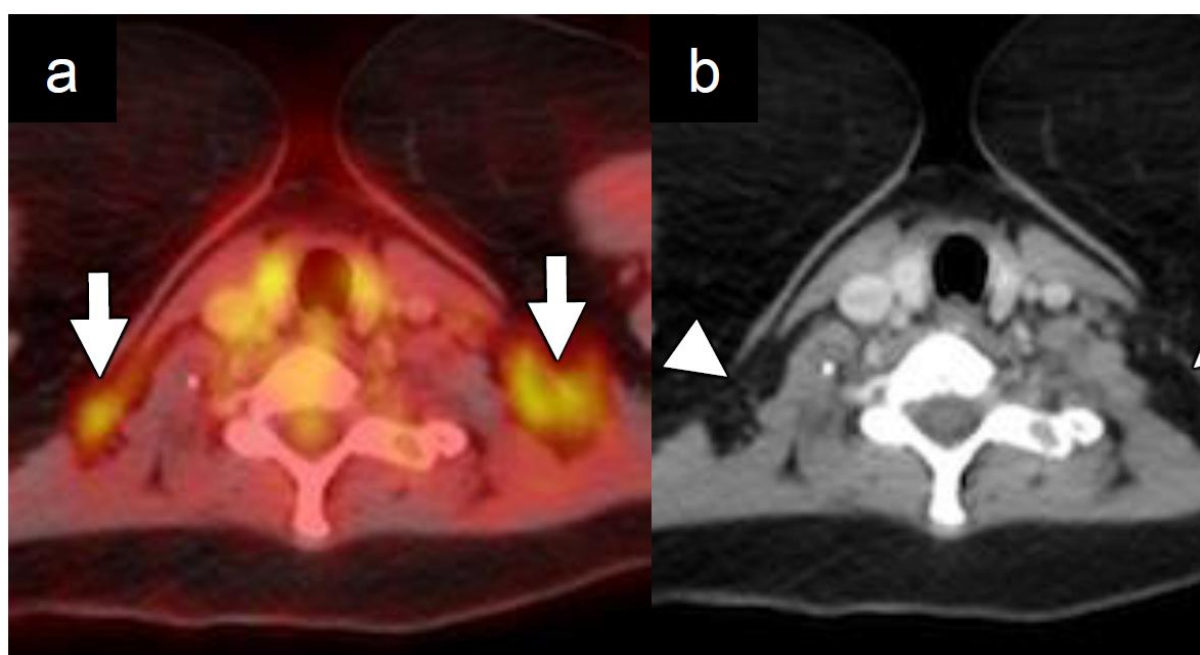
FDG uptake in brown adipose tissue. Fused axial FDG-PET/CT (a) shows bilateral focal FDG uptake within the supraclavicular regions (white arrows). Corresponding axial CECT image shows fat density (white arrowheads) corresponding to areas of uptake on FDG/PET, diagnostic of brown fat.
